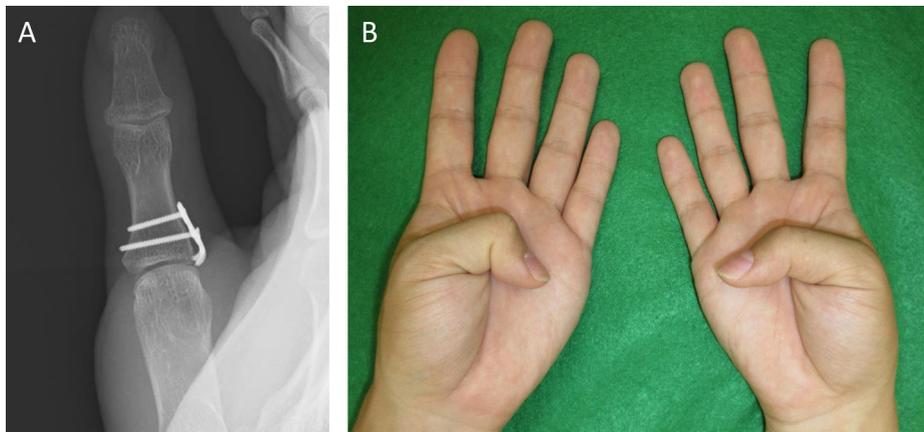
A. A posteroanterior radiograph at 6 months after surgery, showing complete bone union with mild resorption of the bone fragment. B. The range of motion of the thumbs at 6 months after surgery.
